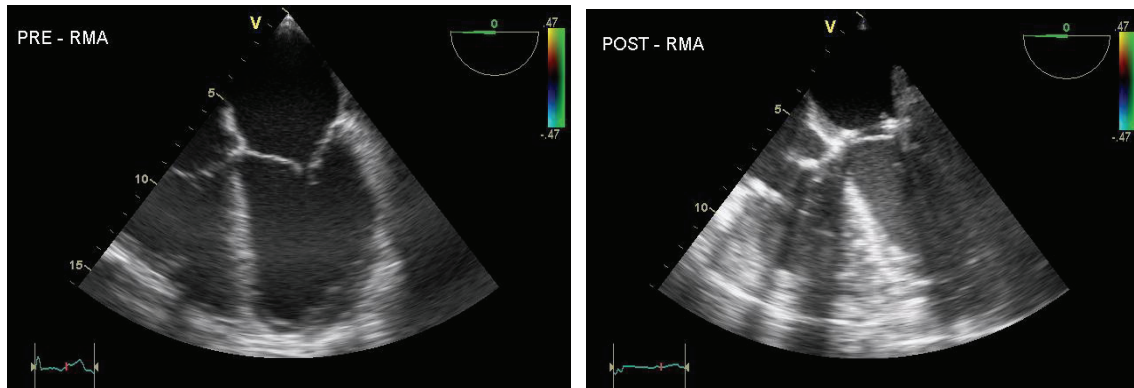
Transesophageal echocardiographic long-axis view before and after restrictive mitral annuloplasty in a 41 year-old patient with ischemic dilated cardiomyopathy (LVEF: 20%) and severe mitral regurgitation (grade 4). Mitral annular dilatation was demonstrated as the relative ratio between the diastolic mitral annular diameter (5.2mm) and the diastolic length of the anterior mitral leaflet (3.6mm) exceeded 1.3 (1.44). Restrictive mitral annuloplasty (Edwards Physio-ring size 26) was performed and postoperative mitral leaflet coaptation was 12mm with a normal inflow pressure gradient (3.5mmHg) and no residual mitral regurgitation. Additional restrictive tricuspidal ring annuloplasty was performed for severe tricuspidal regurgitation (grade 3)
